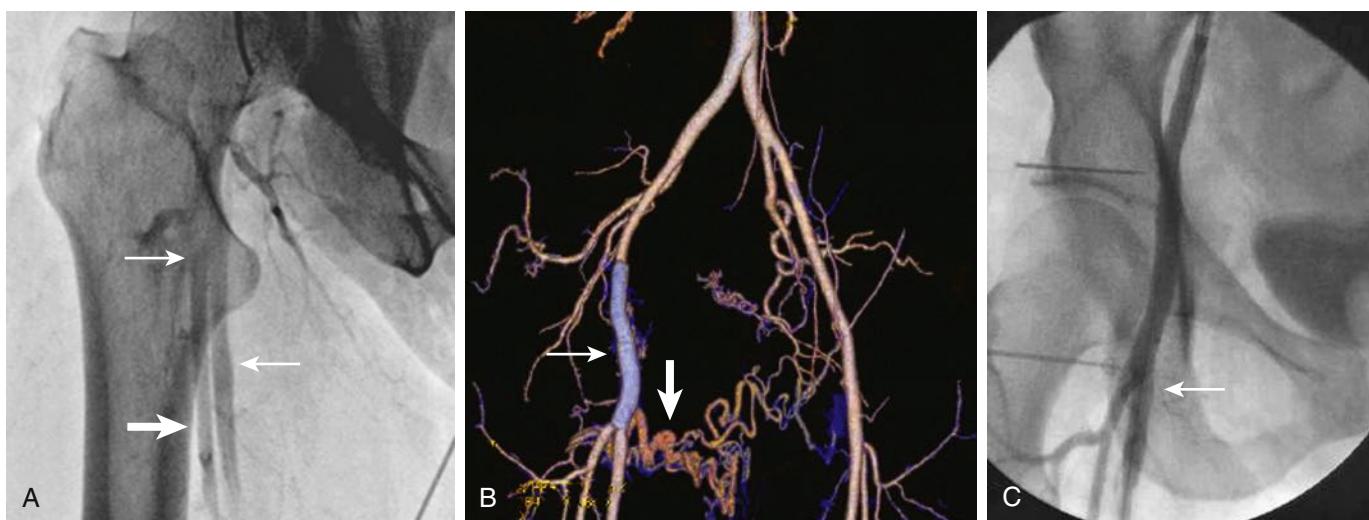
(A) Selective femoral angiogram demonstrating an arteriovenous fistula (AVF; upper arrow) at the common femoral bifurcation, outlining the superficial femoral vein (middle arrow) and artery (lower arrow). (B) CT reconstruction showing persistence of the AVF (vertical arrow) below a covered stent graft (horizontal arrow) used to treat common femoral stenosis after attempted operative repair of the fistula. (C) Selective femoral angiogram demonstrating closure of the fistula after placement of an additional covered stent graft (arrow).
